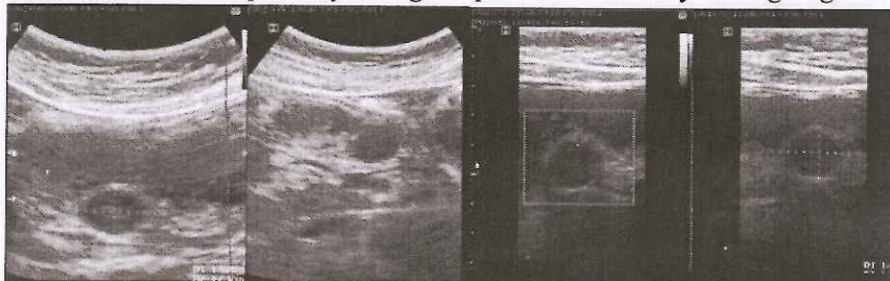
Abdominal Ultrasound showed a homogenous hypoechoic mass located within the posterior gastric wall, protruding into the inner lumen. The mass was oval in shape, had regular and distinct margin without infiltration. There was no gastric wall thickening and the layers remained intact. No evidence of hypervascularity on Color Doppler ultrasound of the mass.
